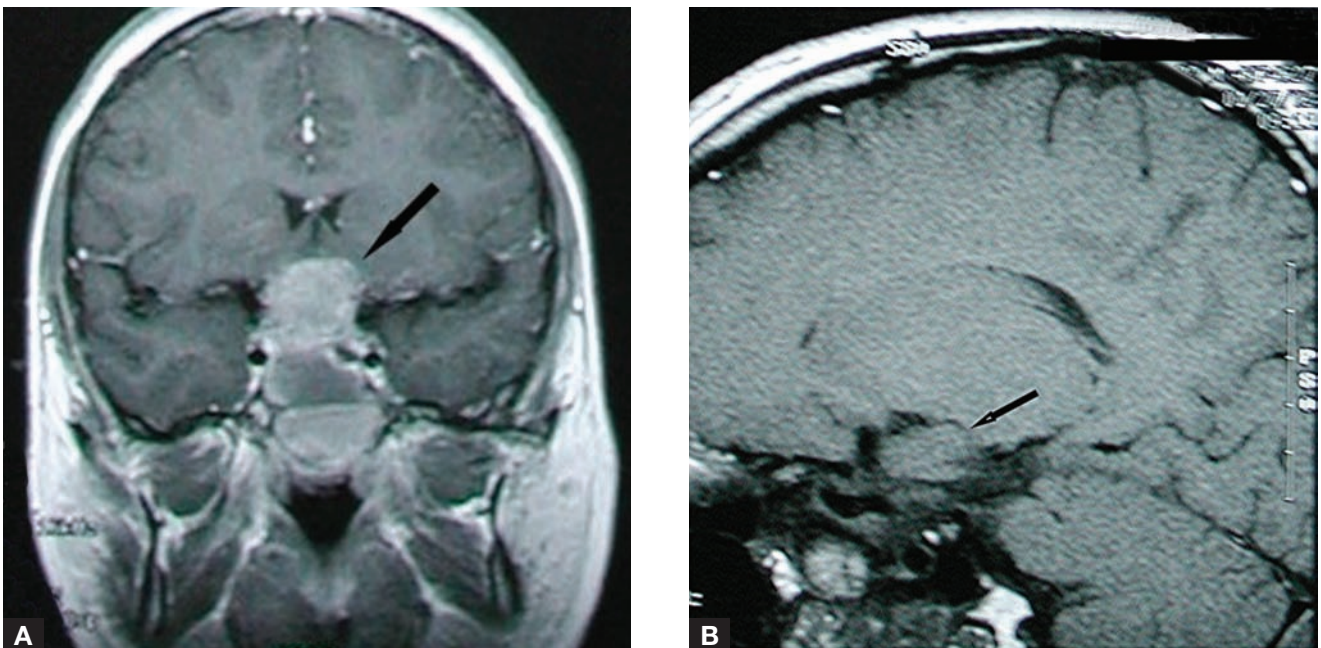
(A) Anteroposterior and (B) sagittal magnetic resonance imaging of brain, demonstrating 2.6 x 2.5 x 5.5-cm suprasellar pituitary tumor (black arrows).
